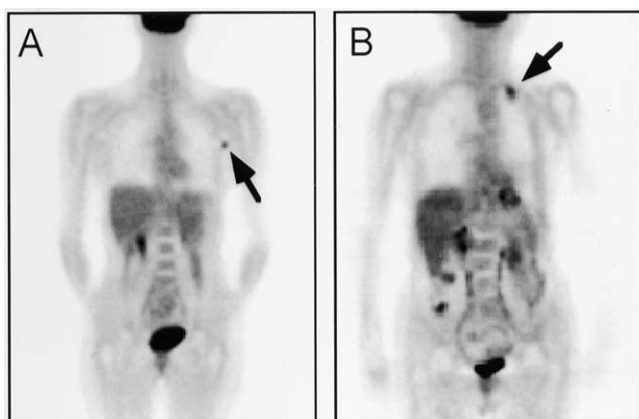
Images of patients using the LSO based ACCEL PET scanner. In each study, the emission and transmission data were collected in a total imaging time of 30 minutes after injection of 13m Ci of FDG. Left: 40 yr old female with primary breast cancer (arrow). Right: 78 yr old male with lung cancer (arrow). Courtesy of Dr. Peter Valk, Northern California PET Center.
